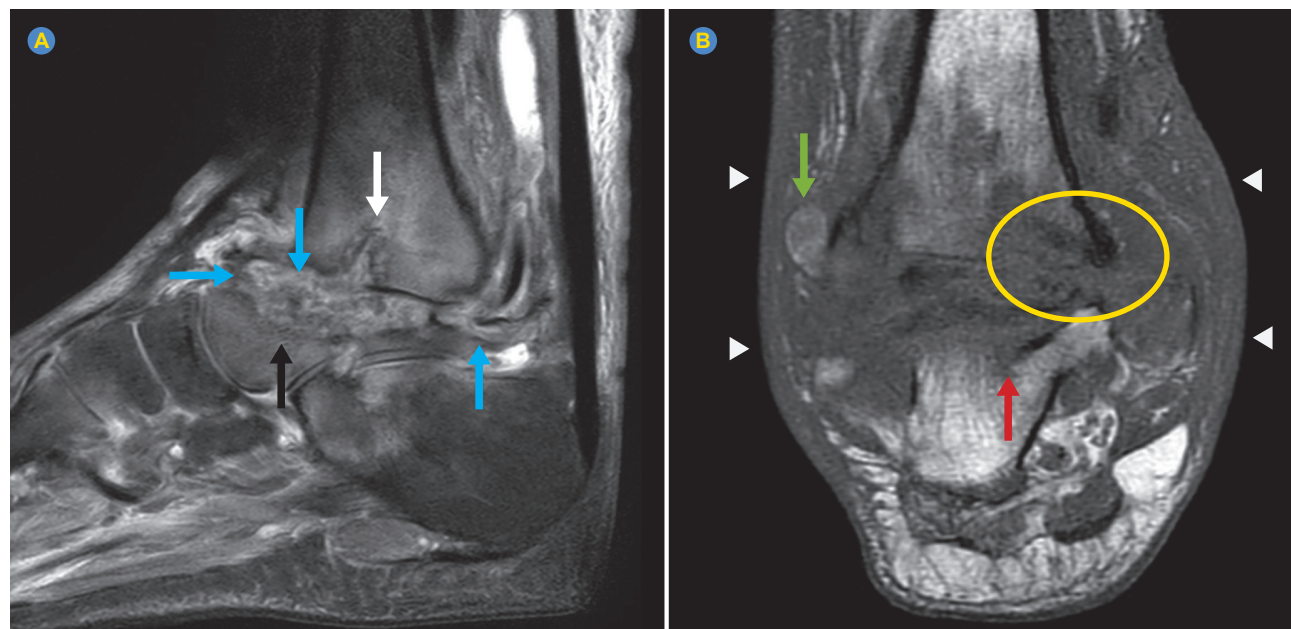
Magnetic resonance imaging DP SPAIR in sagittal section (A) and T1-weighted image in coronal section (B) of the right ankle demonstrating marked deformity with erosions and significant edema of the dorsal portion of the talus bone (black arrow). Erosions with significant edema in the distal and articular portion of the tibia with communication with the medullary collection (white arrow). Marked deformity and volumetric reduction of the medial malleolus (yellow circle). Deformity with erosions and significant edema of the dorsal portion of the calcaneus bone (red arrow). Fluid effusion with significant synovial thickening in the tibio-talar joint space and in the anterior and posterior tibio-talar recesses (blue arrows). Significant edema of the subcutaneous tissue (arrowheads) with associated abscess (green arrow).
